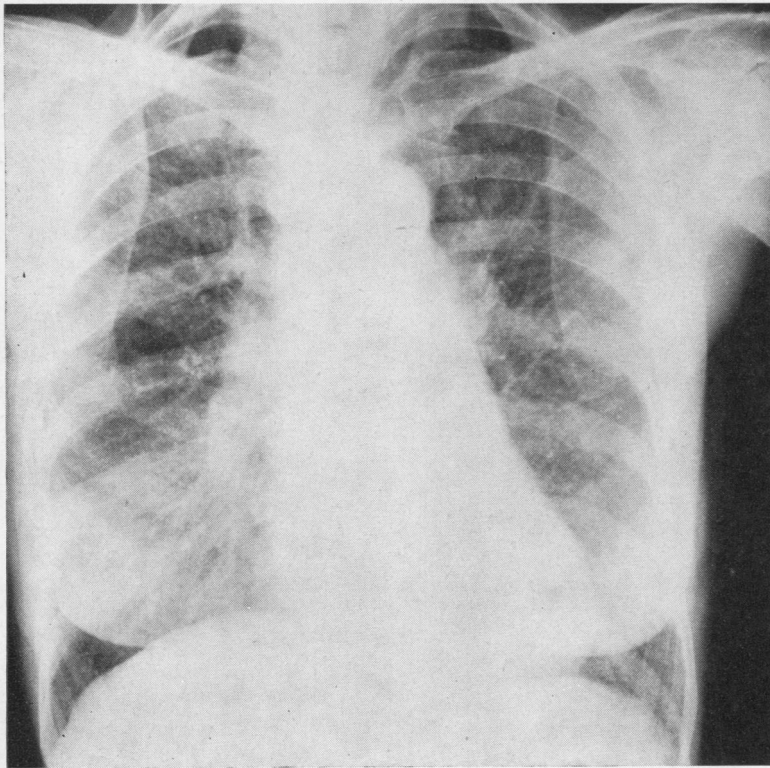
(a) *Moderate acute changes. Grade A2.* (b) *Similar change demonstrated by macro-radiography.*
